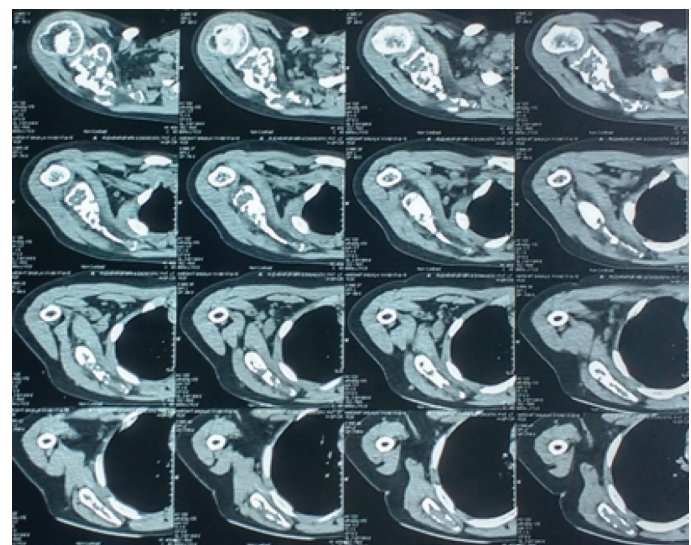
MRI showing infiltration of scapula with soft tissue edema of the right shoulder.
